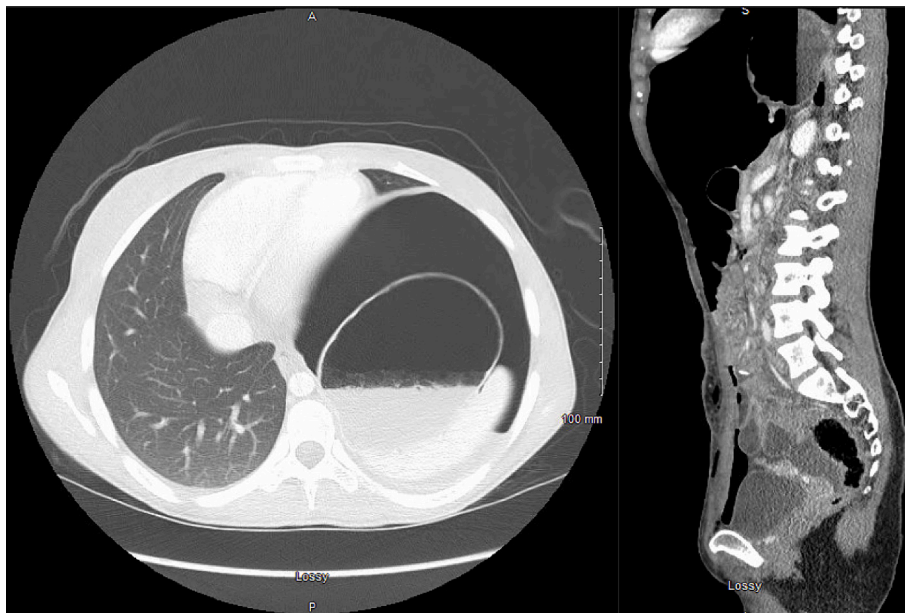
CT A/P demonstrating large volume pneumoperitoneum with a left upper quadrant air-fluid level, small volume free fluid, significant elevation of the left hemidiaphragm, and rightward mediastinal shift.
